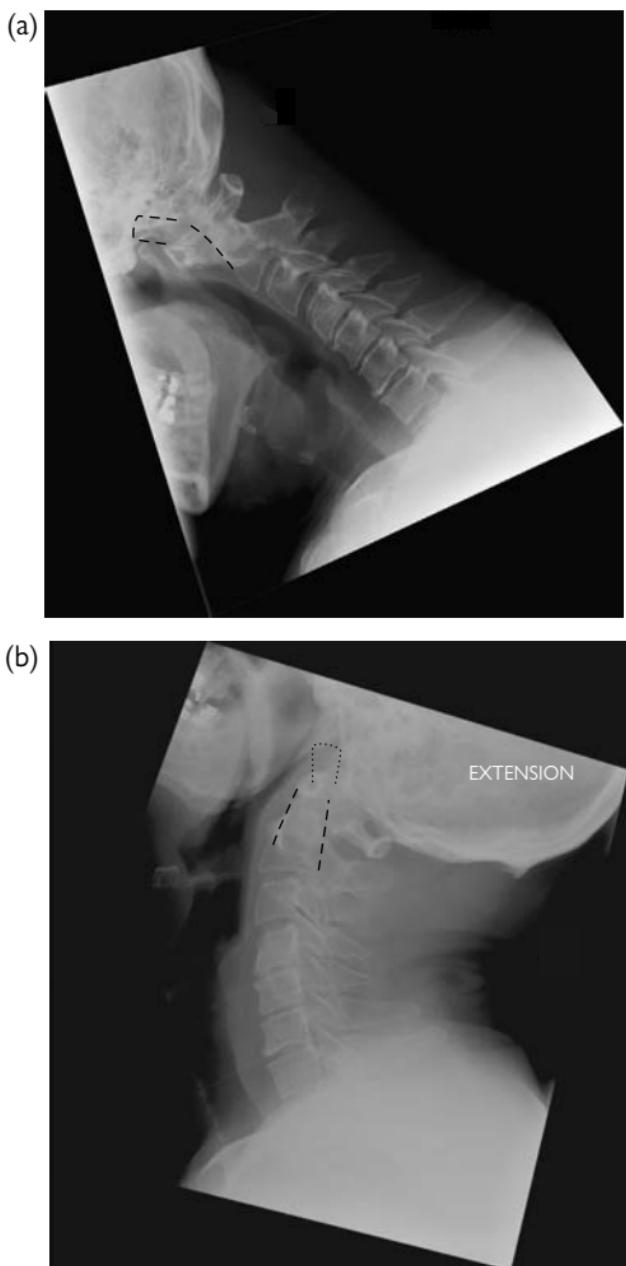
Type 2 odontoid peg fracture. (a) and (b) Flexion and extension plain X-ray. Dynamic plain X-rays demonstrate marked instability at the atlanto-axial joint as a result of a fracture through the odontoid peg. On flexion, there is marked anterior subluxation of the C1 ring and fracture fragment of C2 (dotted line), in relation to the inferior portion of C2 (dashed line) with consequent reduction in the calibre of the vertebral canal at this level.
